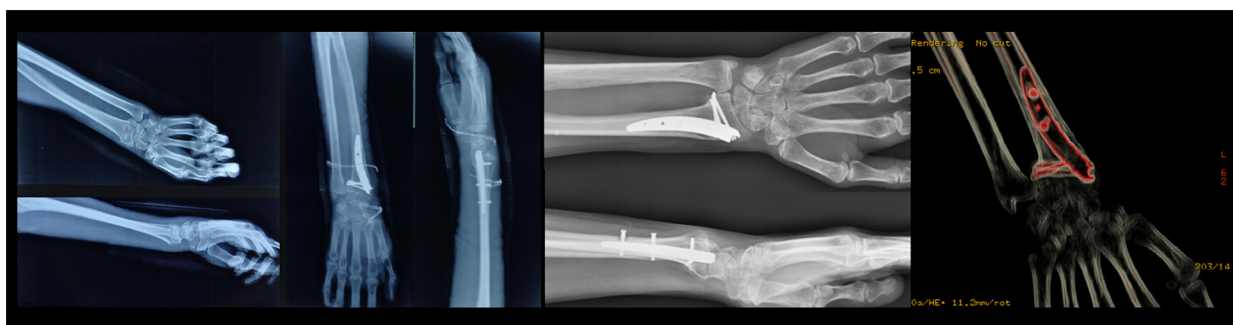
Preoperative, postoperative, and latest follow-up X-ray findings for intramedullary nail fixation and postoperative CT image.
